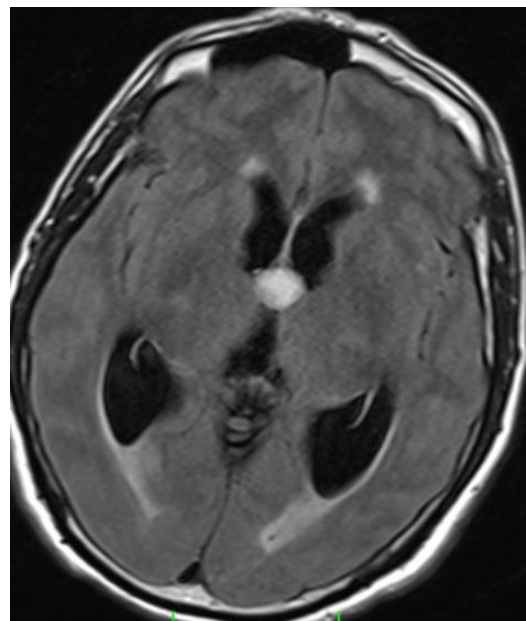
Preoperative cranial MRI image (IV.Ventricule normale).
